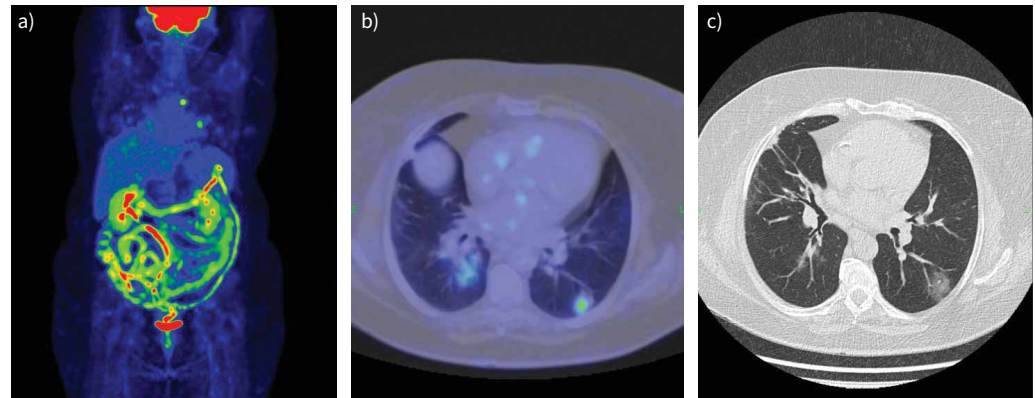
Coronavirus disease 2019 (COVID-19) pneumonia. 2-fluoro-2-deoxy-D-glucose positron emission tomography/computed tomography (FDG-PET/CT). a) PET image; b) fused image; c) chest CT. Images show bilateral, multiple, mainly peripheral, mildly/moderately active ground-glass opacities.
